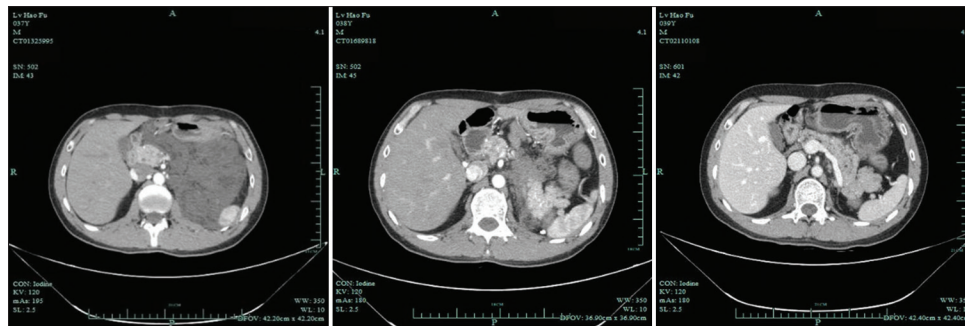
Postoperative follow-up of retroperitoneal tumors with enhanced CT scan of the entire abdomen
